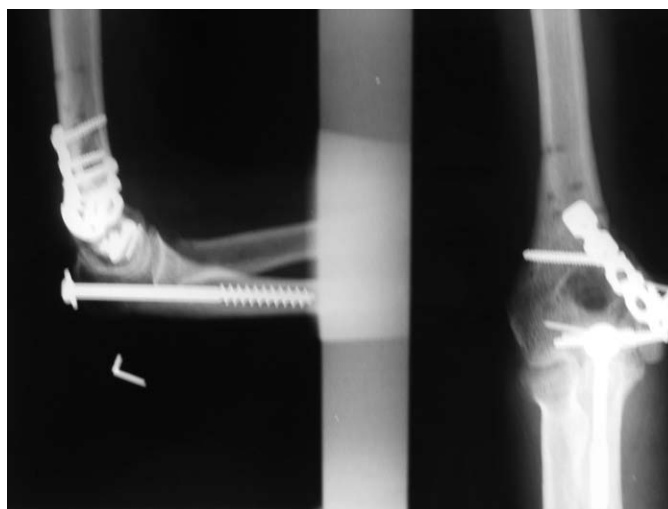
Radiograph of patient 6 showing the surgically implanted metal plates and screws.
